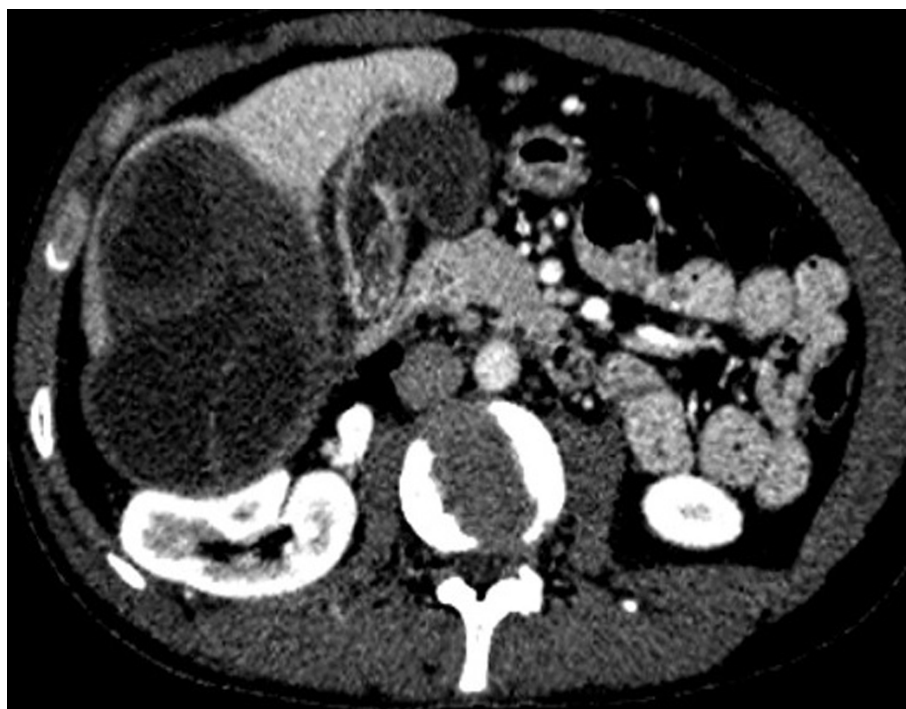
Axial plane computed tomography of the same patient shows exophytic extension of the giant hydatid cyst located in the right lobe of the liver.
